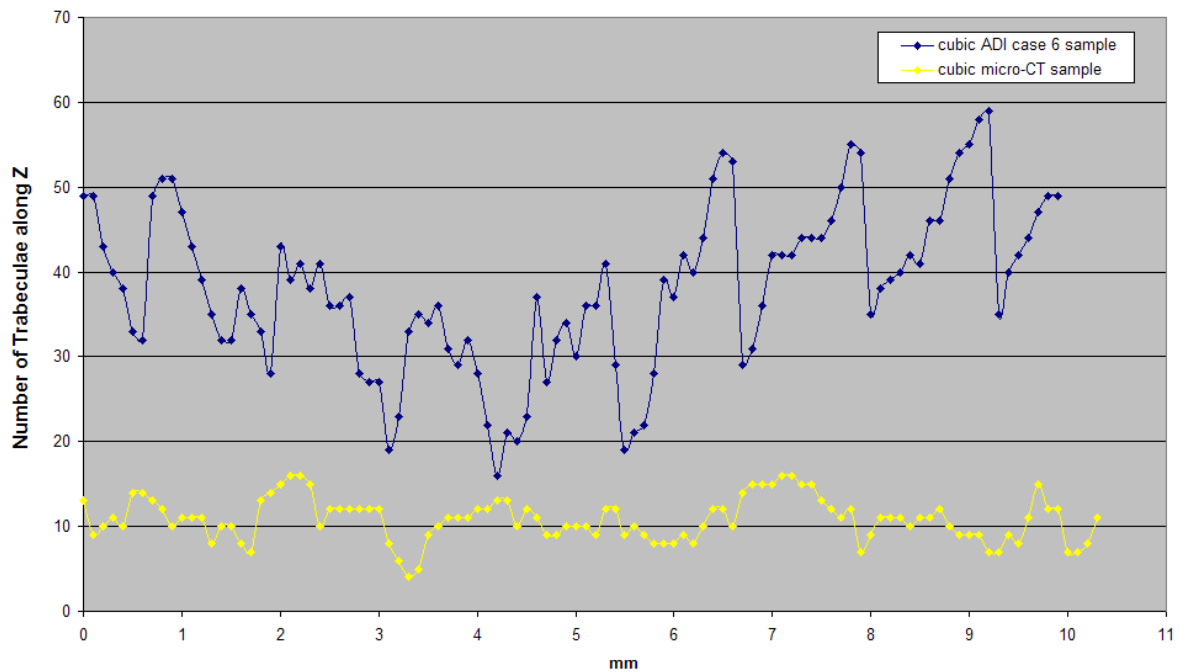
Comparison of trabecular area along *Z* between the cubic ADI case 6 sample and cubic  $\mu$ CT sample
